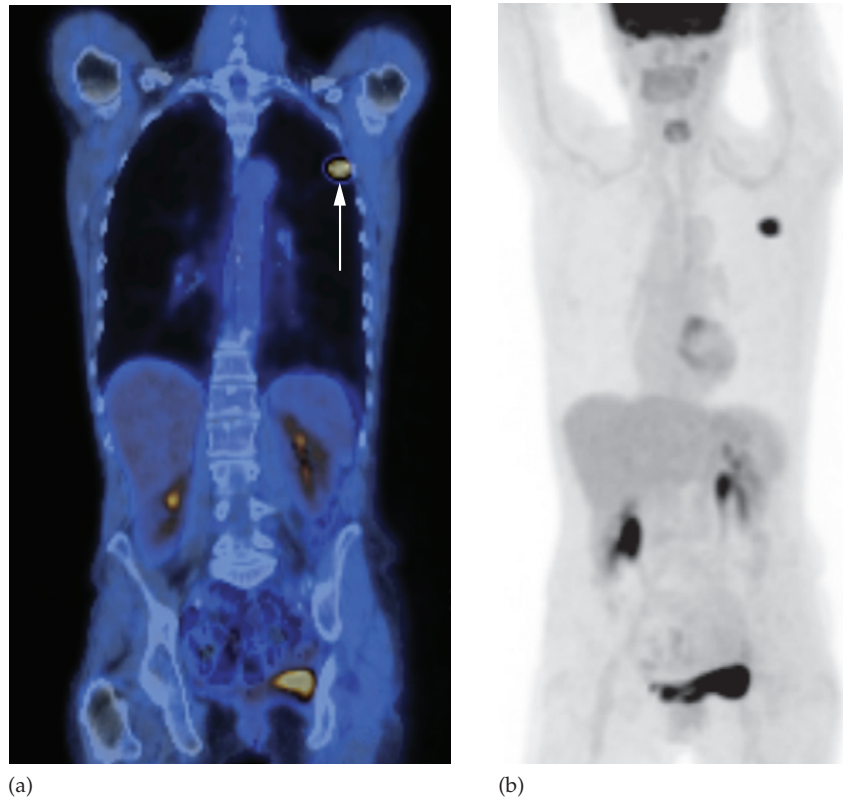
FDG-PET/CT of lung cancer. (a) Coronal fused image and (b) maximum intensity projection, demonstrating a small left lung cancer (arrowed in (a)). The remainder of the FDG uptake is physiological.
